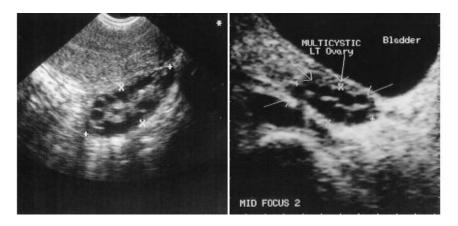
Transvaginal ultrasound scan of a polycystic ovary. (b) Transabdominal ultrasound scan of a multicystic ovary (*Balen, 2008*).
